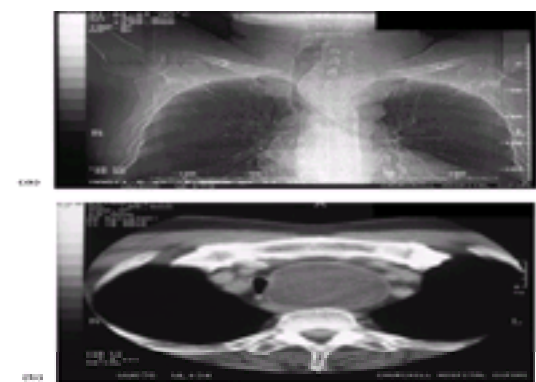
Radiological assessment of a retrosternal goitre by (a) conventional chest radiograph and (b) CT scanning.
